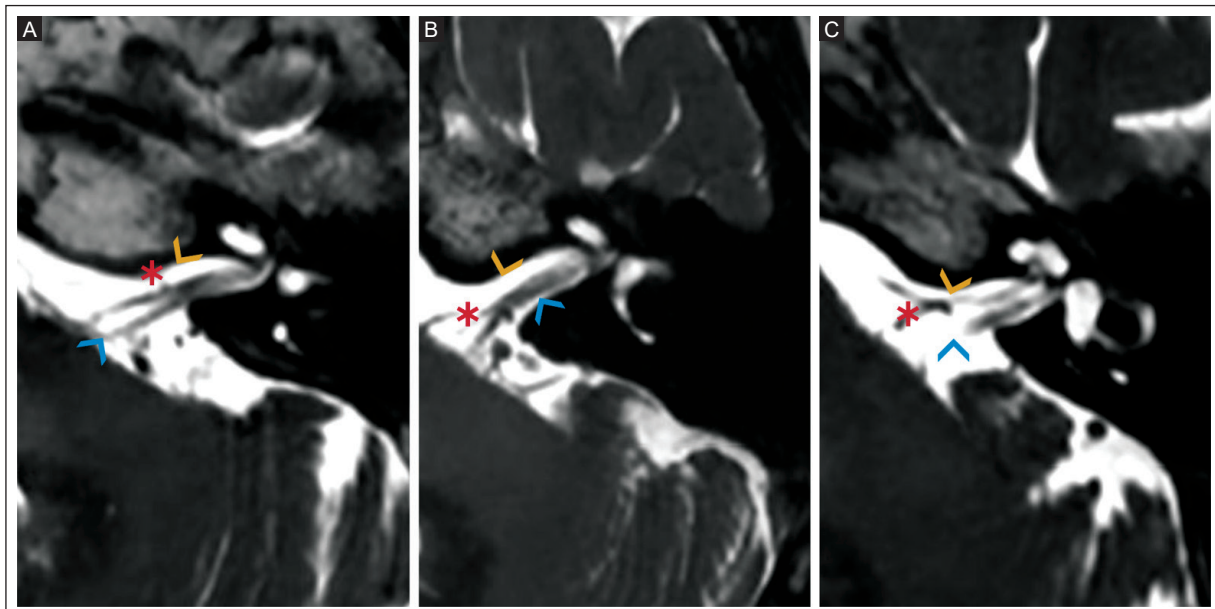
3.0T MRI T2- weighted CUBE shows the Gorrie grade of contact between the vascular loop and the VIII nerve. A: a 72-year-old asymptomatic woman with NVC Gorrie grade A (yellow arrowhead) shows an anteroinferior cerebellar artery loop (asterisk) without contact with the adjacent VII/VIII nerve complex (blue arrowhead). B: a 61-year-old woman with hemifacial spasm, shows NVC Gorrie grade B (yellow arrowhead) with an anteroinferior cerebellar artery loop (asterisk) running adjacent to the VII/VIII nerve complex (blue arrowhead). C: a 58-year-old man with vertigo, shows NVC Gorrie grade C (yellow arrowhead) with an anteroinferior cerebellar artery loop (asterisk) coursing between the VII/VIII nerve complex (blue arrowhead).
